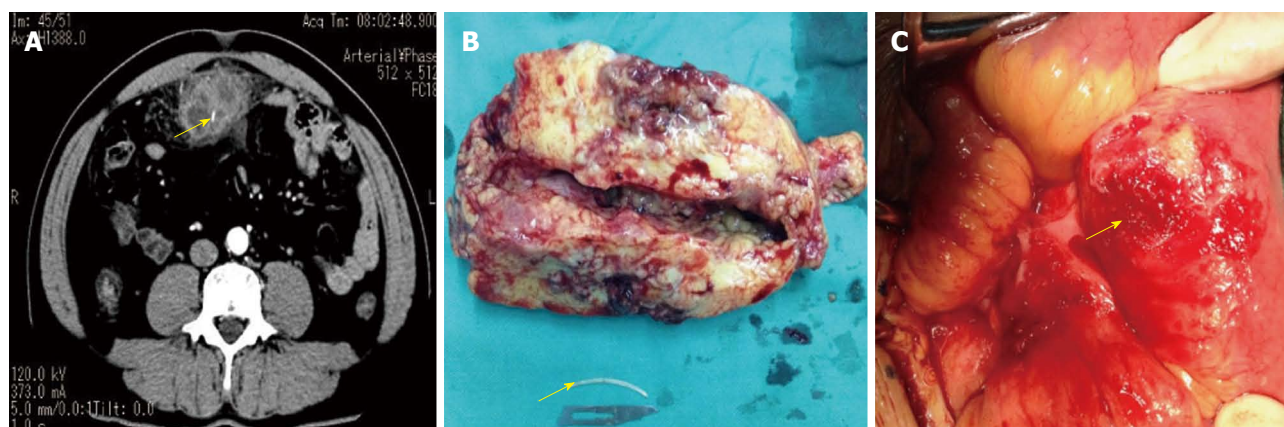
Computed tomography, resected abscess and fish bone and the location of perforation in terminal ileum. A: Axial and sagittal slides of abdominal computed tomography scan. It is visible an undefined liquid collection involving a linear image suggestive of foreign body (arrow); B: The resected abscess size and fishbone (arrow); C: The perforation in terminal ileum (arrow).
